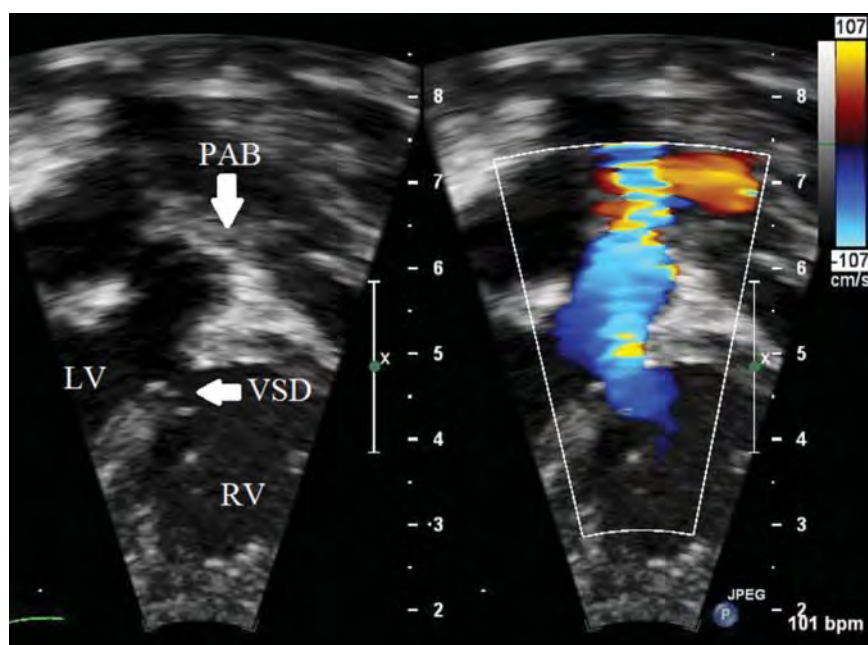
A 2D echocardiography subcostal coronal view in color Doppler mode. A ventricular septal defect is present, which has been palliated using a pulmonary artery band. LV, left ventricle; PAB, pulmonary artery band; VSD, ventricular septal defect; RV, right ventricle.
